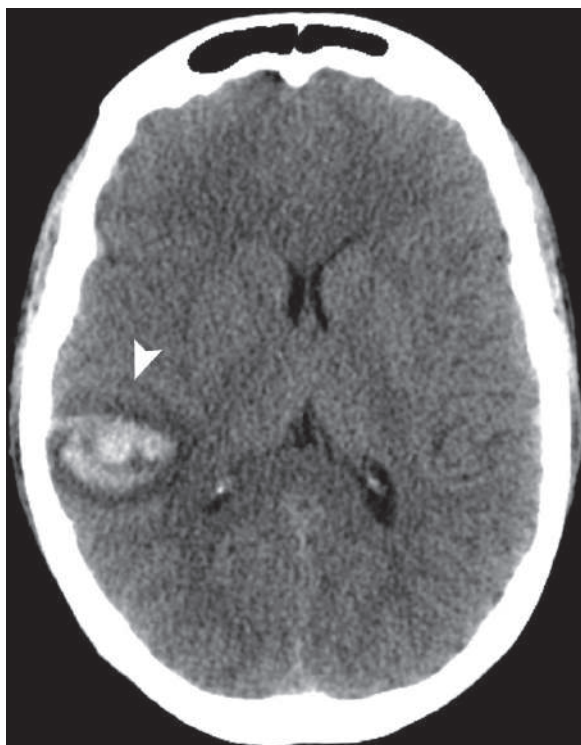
Axial brain nonenhanced CT in a patient with intracranial bleeding due to CAA shows an area of bleeding in the right temporo-occipital region involving the cortices and the corticomedullary junction with a rim of cytotoxic edema (*arrowhead*)
